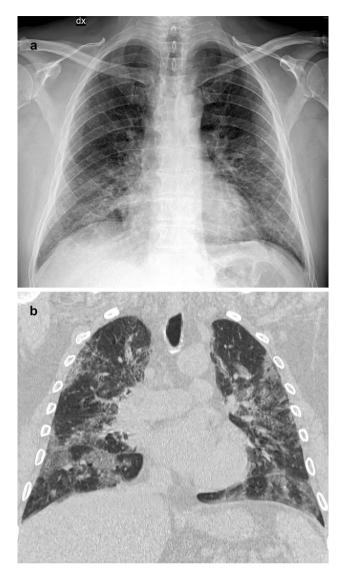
Chest radiograph, PA view (a): multiple, bilateral subtle consolidations in lower and middle zones, with diffuse peribronchovascular interstitial thickening. No pleural effusion is seen. CT scan (breathing artifacts are present): coronal reconstruction (b)
